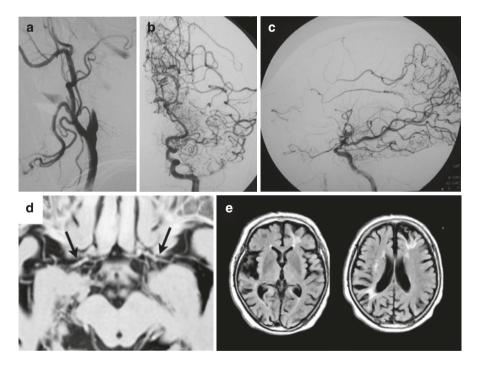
Radiological findings of a 65-year-old female with asymptomatic moyamoya disease. Right carotid angiography (a) shows complete occlusion of the internal carotid artery. The Towne's (b) and lateral views (c) of left internal carotid angiography show an occlusion of supraclinoid portion of the internal carotid artery associated with dilated moyamoya vessels. Inverted image of heavy T2-weighted image (d) demonstrates a marked decrease of outer diameter of the middle cerebral artery on both sides (arrows), which is known specific for moyamoya disease (*see Chap.* 14). FLAIR images (e) reveal old cerebral infarction in the right deep white matter and parietal lobe and left frontal lobe. All of them correspond to the borderzone areas, suggesting the presence of hemodynamic insufficiency
